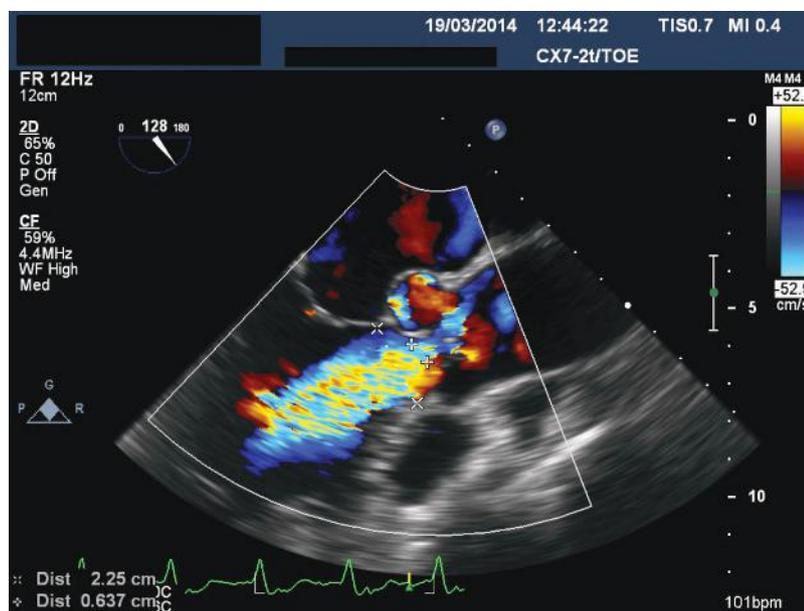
Transesophageal echocardiography image of a color-flow across the aortic valve showing regurgitation in a 64-year-old woman with a history of lobectomy for a bronchial adenoma and dyspnea on exertion (Case 2).
